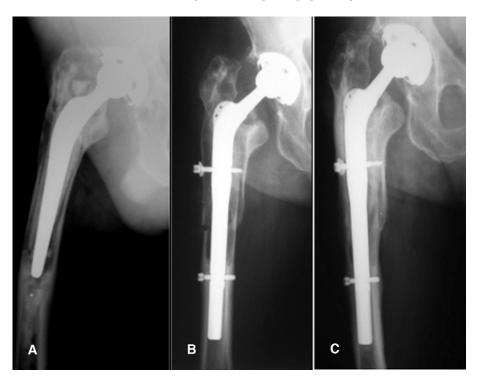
(A) Preoperative X-ray of a 72 year old female with aseptic loosening of a hybrid total hip arthroplasty conducted 9 years prior to presentation. (B) 6 weeks postoperative x-rays of the index revision using the described technique. The transfemoral osteotomy line is still visible. (C) At the 9-year follow-up, the osteotomy has healed, and no stress shielding can be observed. Also note the proximal femoral bone stock regeneration.
